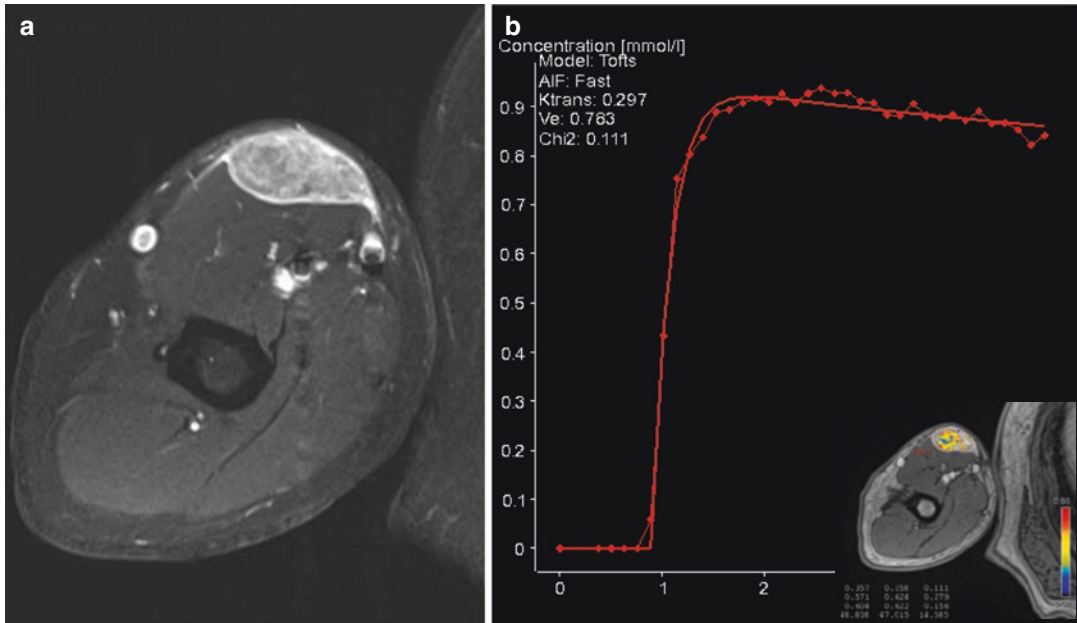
Dynamic contrast-enhanced MRI. Axial post-contrast FS T1WI (a) shows a subfascial soft tissue mass with nonspecific heterogeneous enhancement in the right
